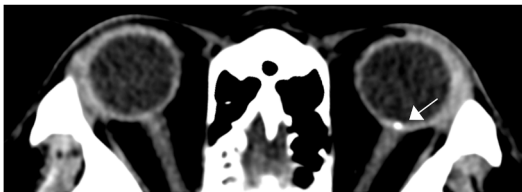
Axial CT showing a calcified left optic nerve head drusen (*white arrow*).
